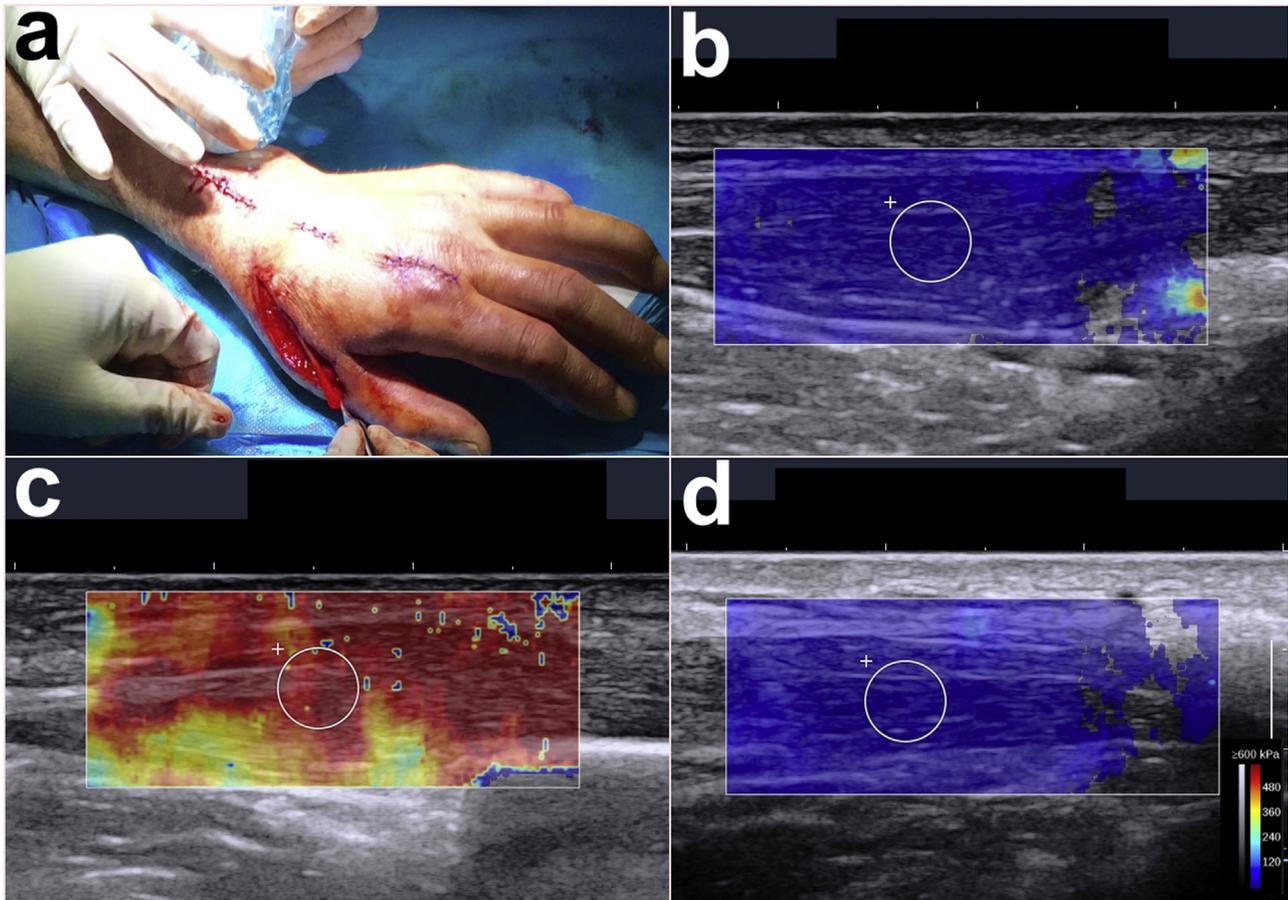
Intraoperative photographs of transfer of the extensor indicis proprius to the extensor pollicis longus using ultrasound shear wave elastography (a). Differences in stiffness values at the various stages of surgery were obtained from rest (b) to active extension during the tendon transfer (c) and at rest after tendon transfer (d).
